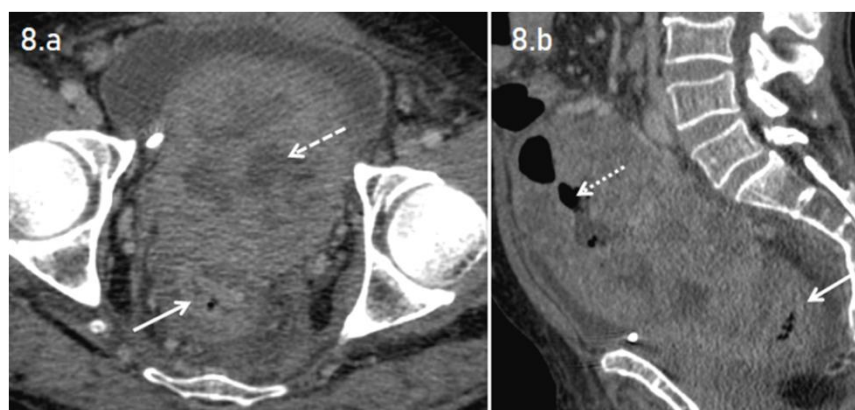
(a & b): 59-year-old case with malignant rectosigmoid GIST. Axial and sagittal views (a and b) of contrast-enhanced CT study of abdomen in venous phase show a large, well-defined, heterogeneously enhancing, exophytic soft tissue mass lesion with central non-enhancing necrotic areas (dashed arrow) and multiple air pockets (dotted arrow) arising from the rectosigmoid junction (solid arrow).
